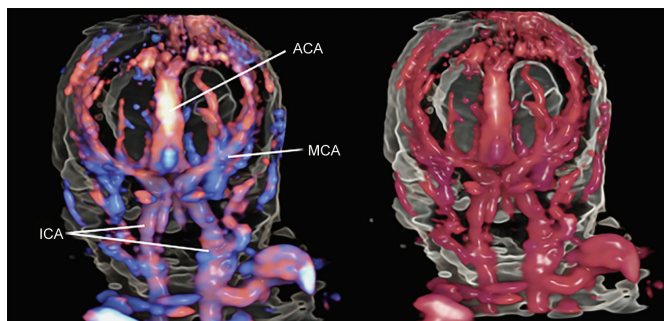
Cervicocranial vascular hemodynamic structure at 13 weeks of gestation: Left: Bidirectional power Doppler HDlive flow image of brain vasculature of a 12-week fetus, and Right: The same ultrasound angiogram dataset with monocolor demonstration; (ACA: anterior cerebral artery; MCA: middle cerebral artery; ICA: internal carotid artery)
